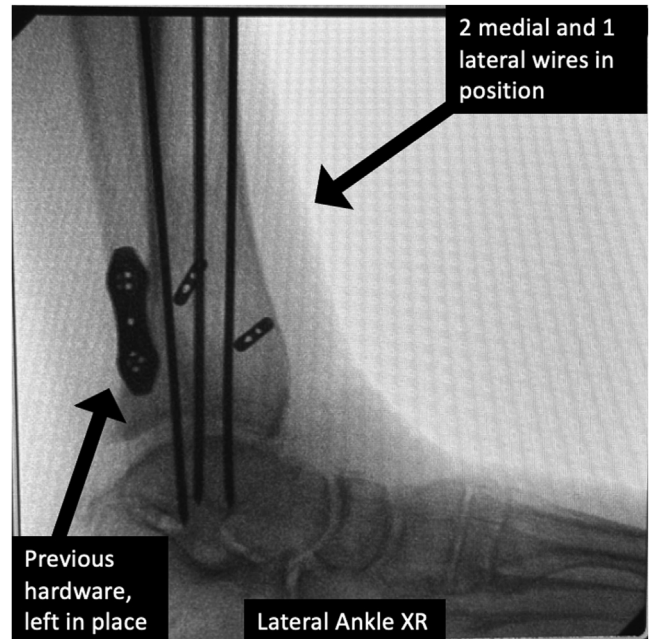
Lateral ankle radiograph view of the tibiotalar guidewires in place. This patient had previous hardware; Syndesmosis TightRope (Arthrex) with two-hole lateral fibular plate, visualized here, was left in place. We ensure that wire is not crossing the subtalar joint.
